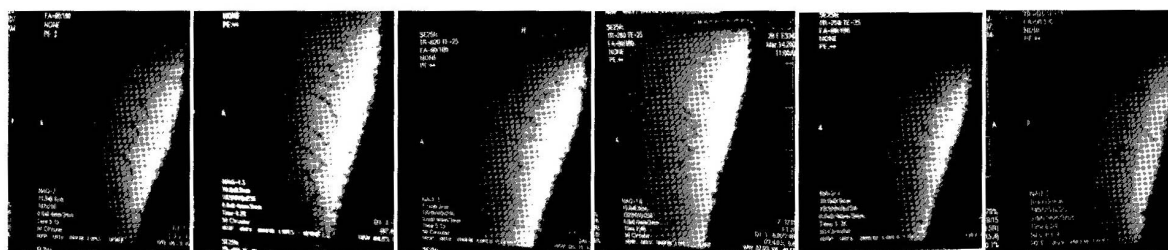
Sagittal plane T1-weighted pre and post-treatment images of patients 1, 2 and 3.
